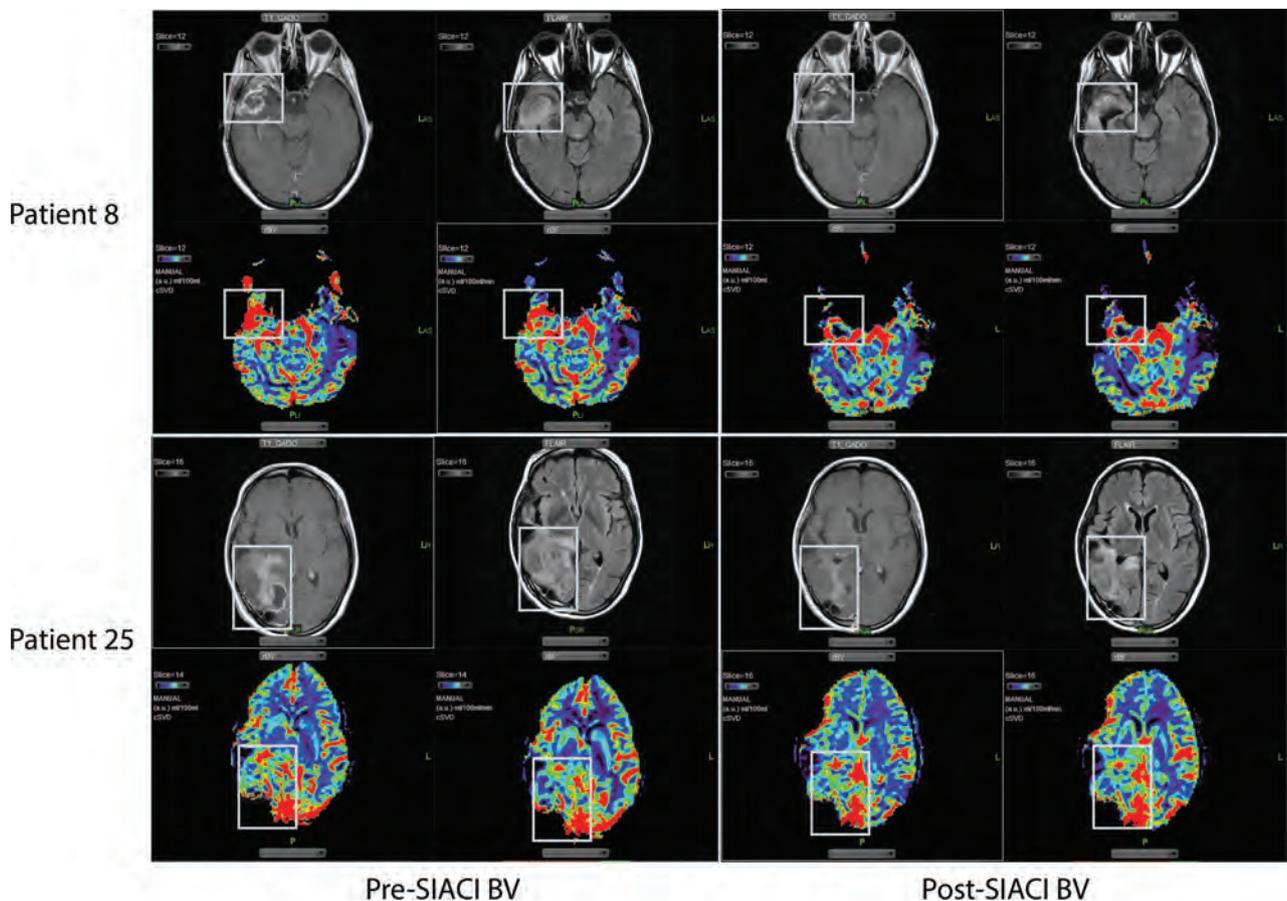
MR imaging changes from SIACI BV treatment. Imaging from 2 patients (study patients 8 and 25) demonstrates a decrease in contrast enhancement, T2 signal abnormalities, rCBV, and rCBF following SIACI BV.
